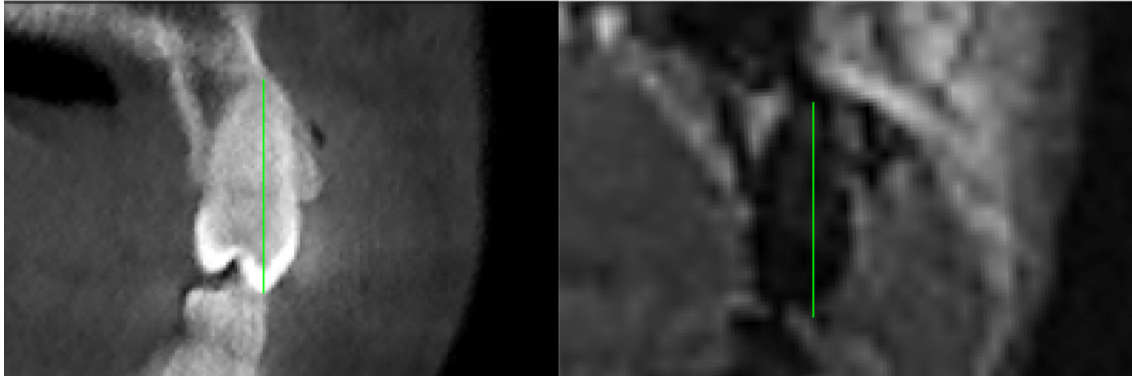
Measurement of an incisor. Shown here is a maxillary left central incisor on CBCT slice (left) and MRI slice (right). Maxillary incisors were measured from the most inferior point on the incisal edge to the most superior point on the root.
